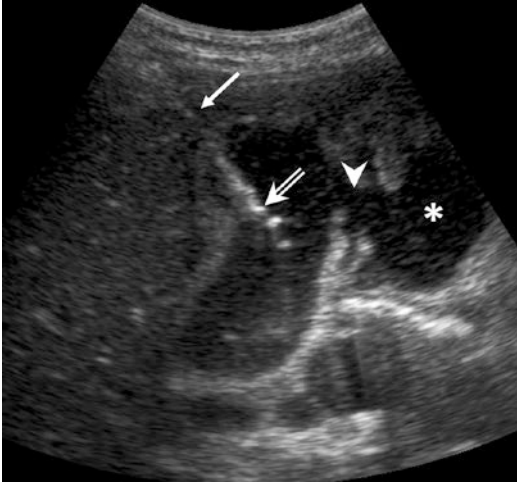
Cholecystostomy. Ultrasonography guided percutaneous cholecystostomy (open arrow) through transhepatic route (arrow) in a case of complicated cholecystitis with perforation (arrow head) and pericholecystic collection (asterisk)
